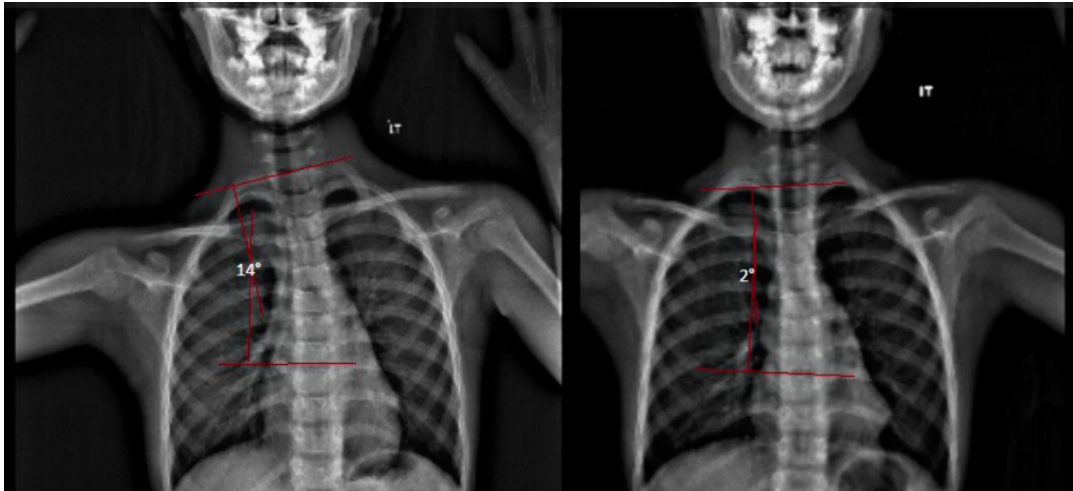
8 years old male with standing spine frontal images. Thoracic convexity of the thoracolumbar curve was seen with a Cobb angle of 13° (left). Repeat radiograph after chiropractic treatment showed a reduction of the thoracolumbar curve to 2° (right)
